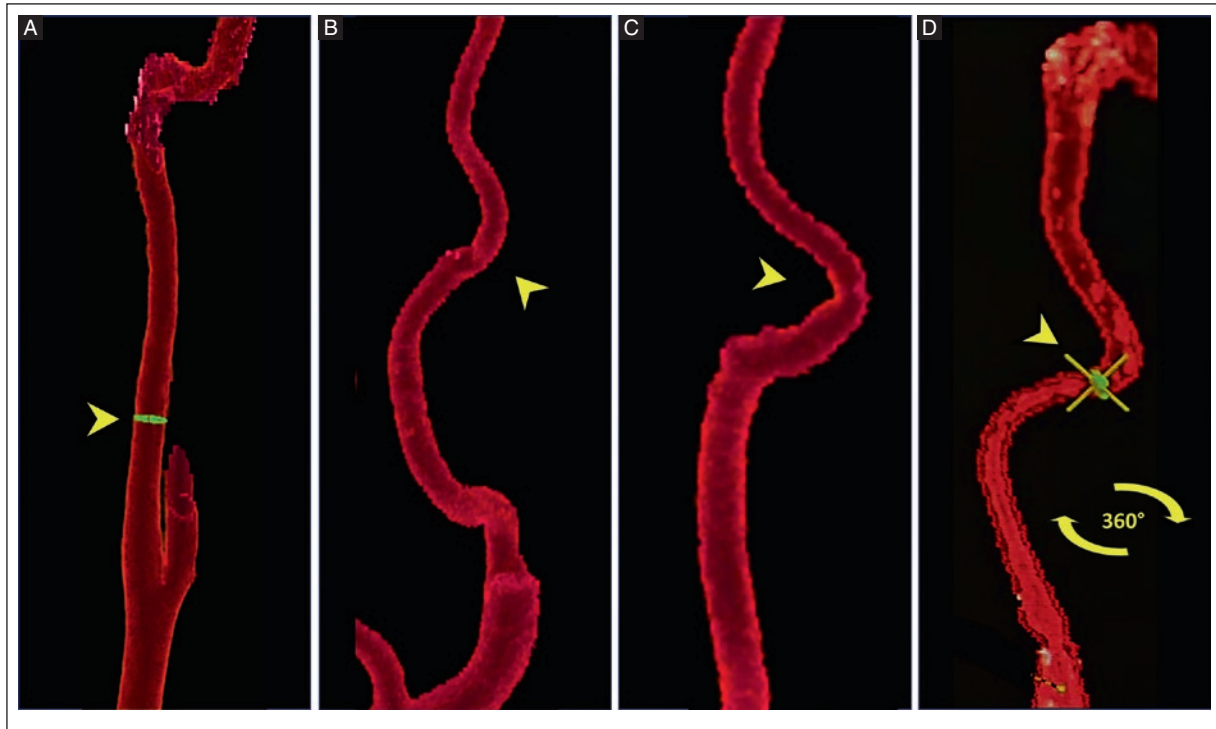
Frontal views of neck CTA VR reconstructions showing different EICA dolichoarteriopathy types. A: the right EICA of a 23-year-old man shows no dolichoarteriopathy (arrowhead). B: tortuosity type in the left EICA and C: kinking type in the right EICA of a 78-year-old woman (arrowheads). D: coiling type in the right EICA (arrowhead) of an 83-year-old woman with the vessel rotating 360° around its axis, characteristic of this morphology.
